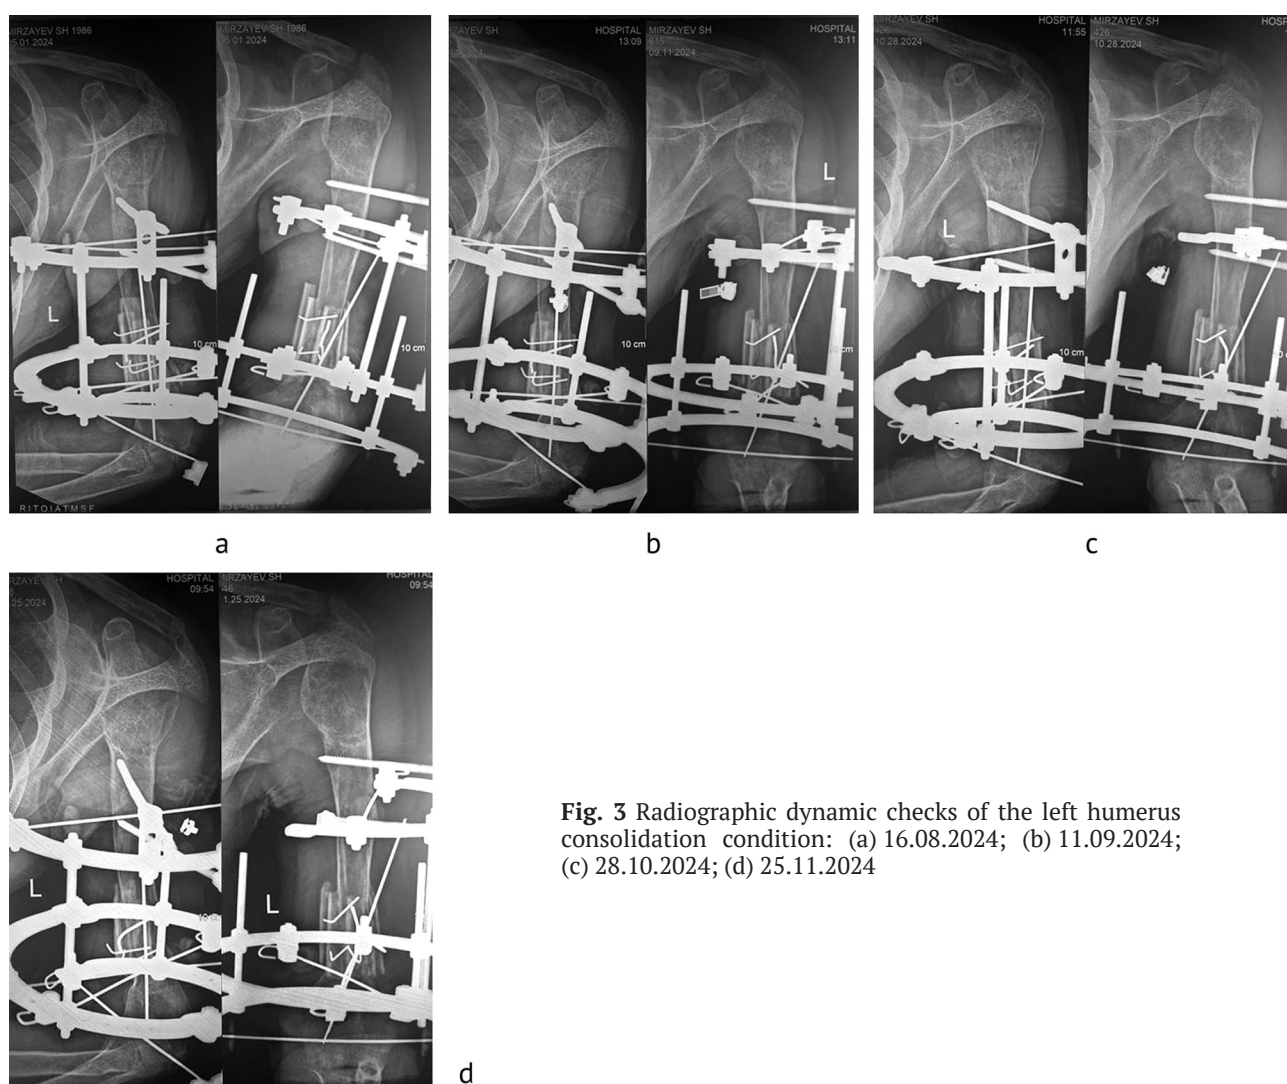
Radiographic dynamic checks of the left humerus consolidation condition: (a) 16.08.2024; (b) 11.09.2024; (c) 28.10.2024; (d) 25.11.2024
